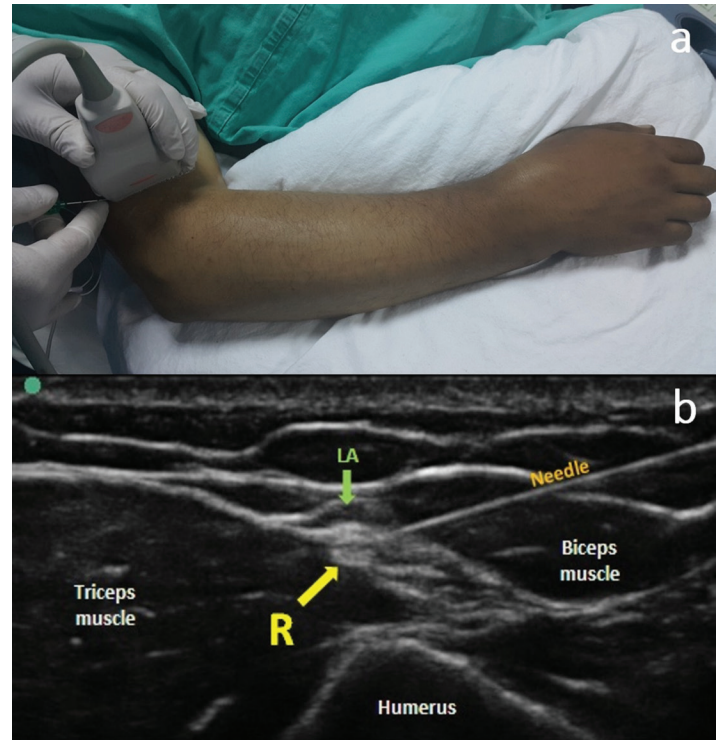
Placement of the ultrasound probe in the supracondylar radial nerve block. The elbow was placed at a 90° flexion and the linear probe was transversely placed 3–4 cm above the lateral elbow, 2b. The transverse image shows the ultrasonographic anatomy of the target area for the supracondylar radial nerve block and the distribution of the local anesthetic drug (R: Radial nerve, LA: Local anesthetic drug).
